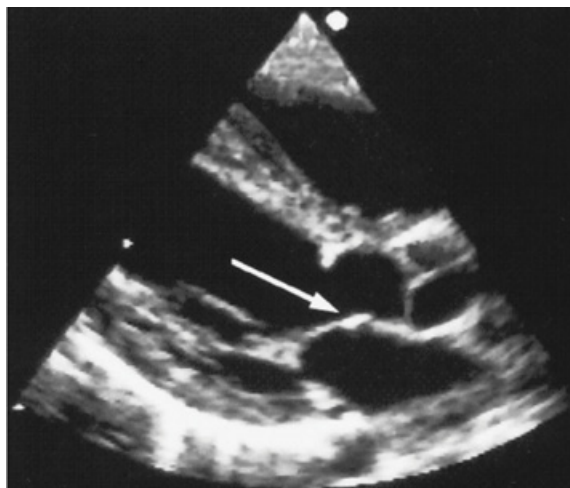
Parasternal long axis view of subvalvular aortic stenosis with membrane.
